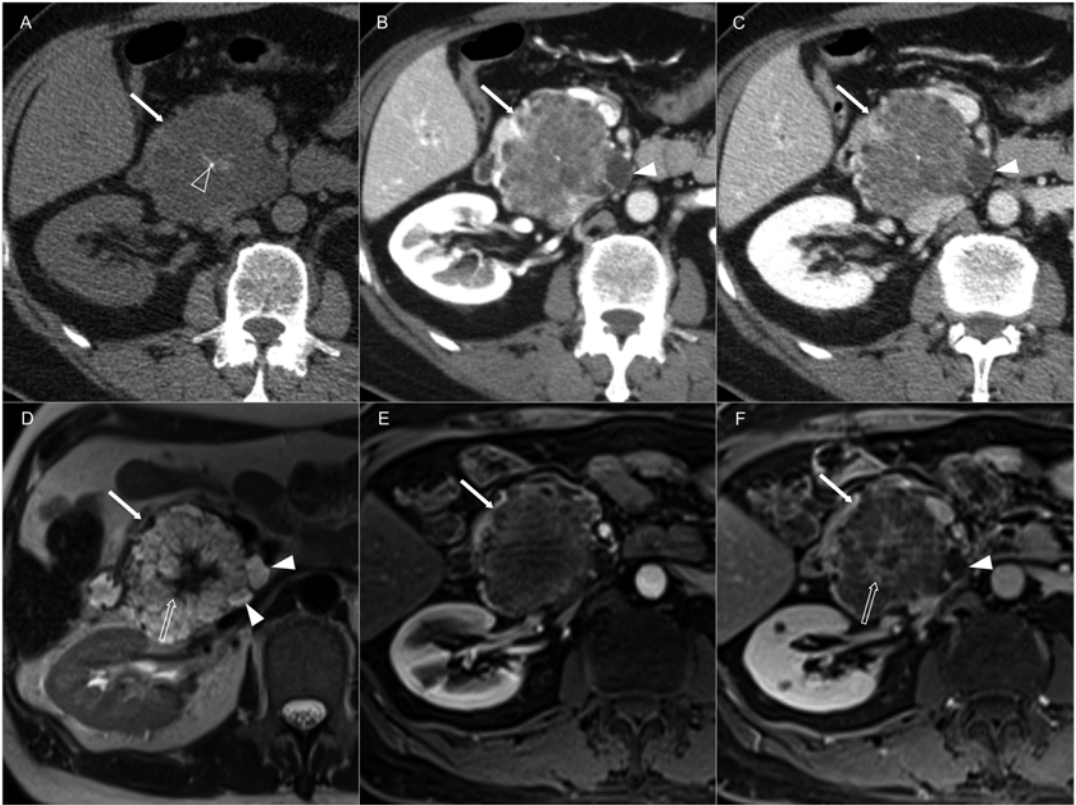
Typical imaging findings of a patient with microcystic serous cystic adenoma. In the axial unenhanced CT image (a), the lesion (arrow) has central calcifications (open arrowhead) and in the DCE imaging [late arterial (b) and portal venous (c) phases], it shows relatively early, mild contrast enhancement. It is composed of multiple very small cysts in the central part and a few
